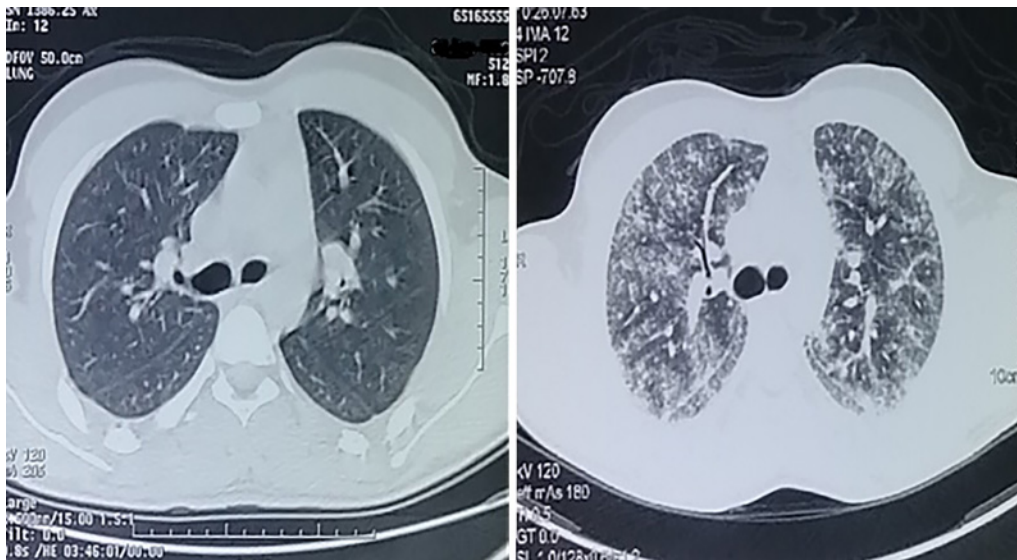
Chest CT scan: normal, when patient was admitted (left) – diffuse crazy-paving pattern (right).
